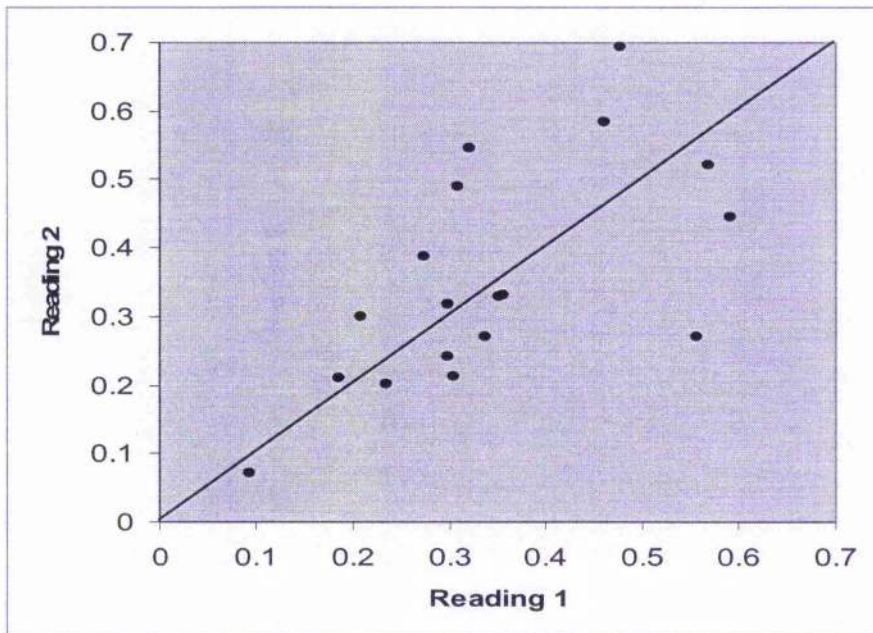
Correlation of duplicate Doppler Perfusion Index (DPI) for a single observer.
